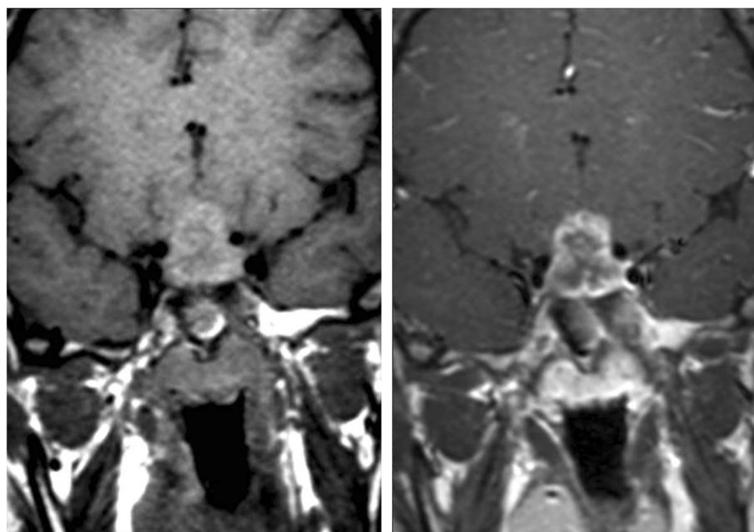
A coronal T1-weighted image (left) revealed a iso/hypo-intense sellar lesion with a su-prasellar extension. A gadolinium enhanced image (right) demonstrated an enhancing lesion with a hypointense center
